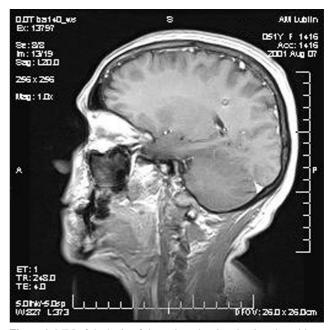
MRI of the brain of the patient showing the ring-shaped lowintensity lesion in the posterior parietal lobe, toxoplasmosis lesion.
